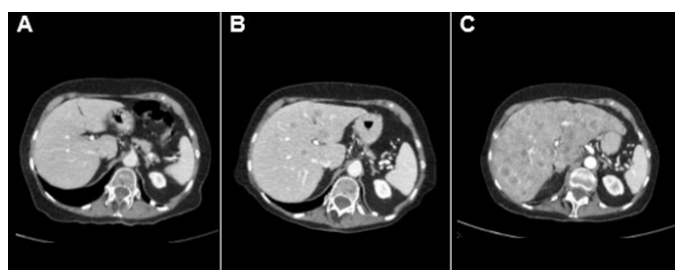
Computed tomography (CT) imaging showing progression of liver metastases with intravenous contrast. (A) CT imaging of liver four weeks preoperatively—no evidence of metastases. (B) CT imaging of liver day 12 postoperatively—multiple liver metastases present. (C) CT imaging of liver at six week follow-up—innumerable liver metastases, liver largely replaced by metastatic disease.
